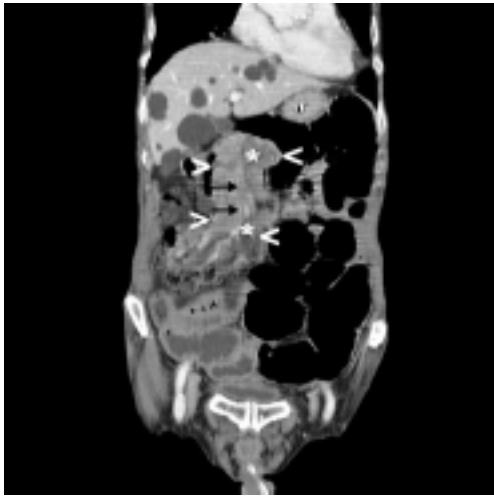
Coronal abdominal contrast CT showing the mass extending from the subhepatic to the upper iliac region (arrowheads), with fat density (asterisks) and blood vessels (black arrows). There are multiple liver secondaries (hypodensities).
